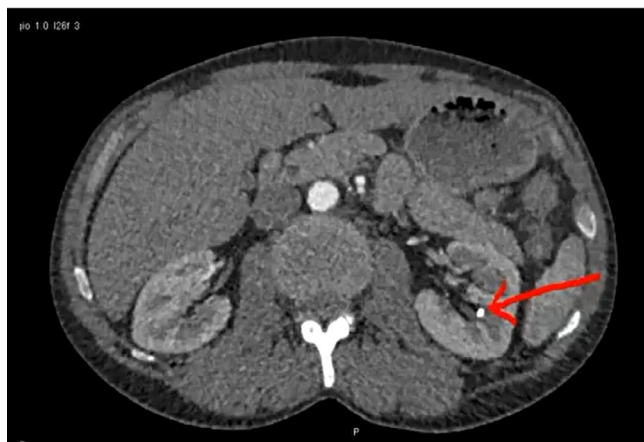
Computed tomography image of 6 mm calculus in the middle pole of left donor kidney as pointed by arrow
